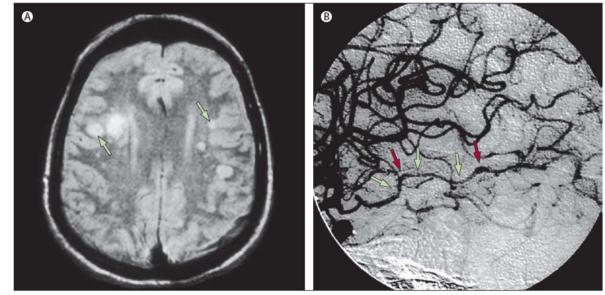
MRI scan and cerebral angiogram of patients with VZV vasculopathies
